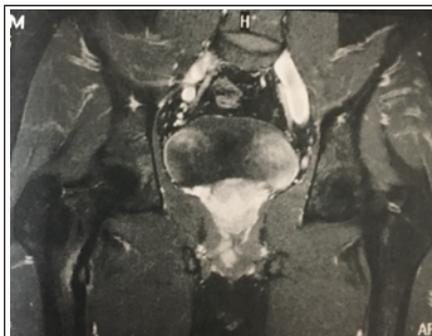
Magnetic resonance imaging of the pre-operative coronal section where we see a small oval area in the middle of the medial bone cortex of the proximal femoral shaft, just below the small trochanter, measuring about 6mm, associated with regional bone cortical thickening, surrounded by bone edema.
